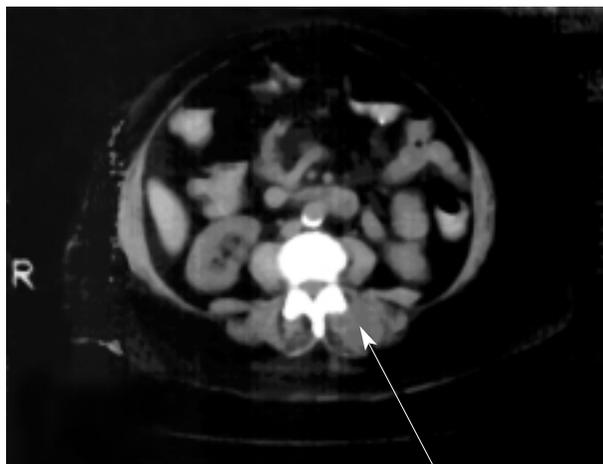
Computed tomography scan shows swelling in the left erector spinal muscle posterior to vertebrae L₃ and L₄ (arrow).
